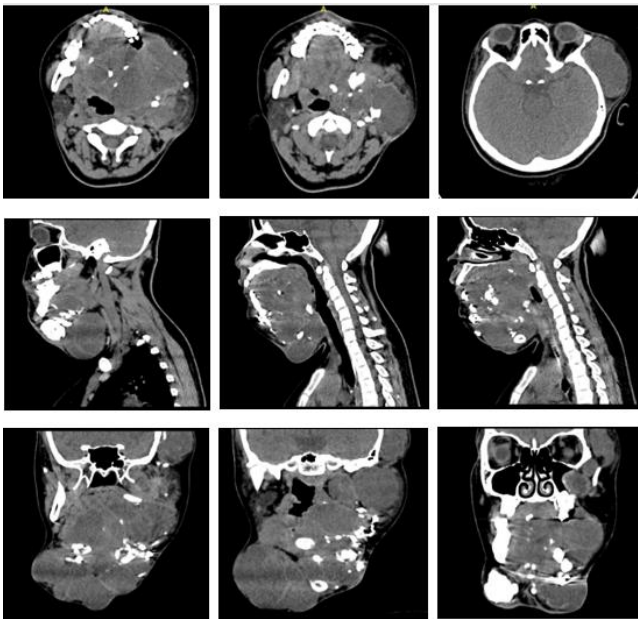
An axial, sagittal and coronal view of the Computed Tomography (CT) scan shows heterogenous enhancing mass involving bilateral submandibular extending to left temporal area with some region of coarse and dense calcifications
